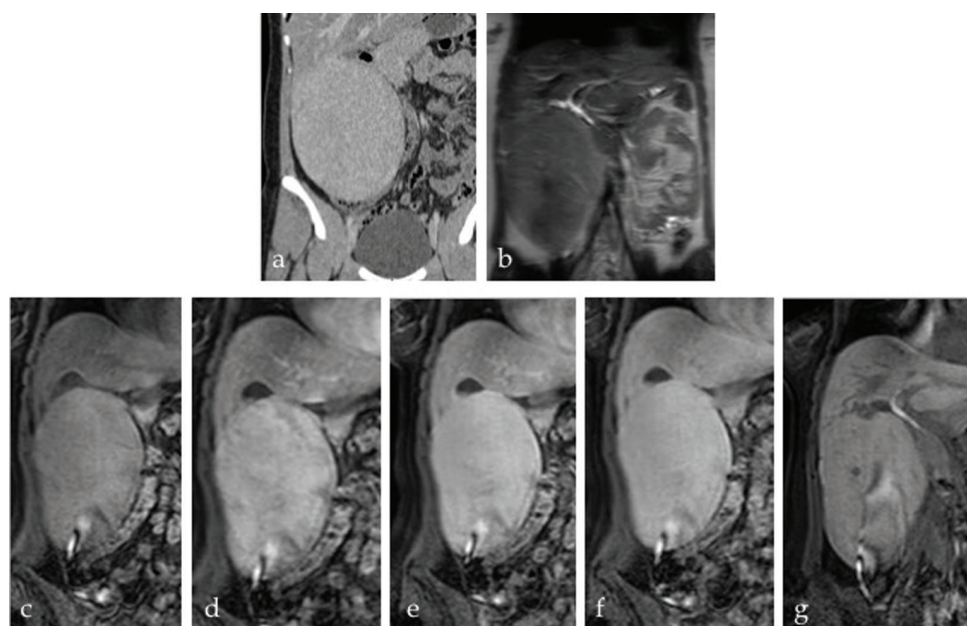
Large exophytic hepatocellular adenoma in a young woman with recent miscarriage, and a prior history of contraceptive pill usage. a. Computed tomography shows a solid liver exophytic mass with background fatty liver. b. T2W coronal image of the lesion. c–f. Arterial to delayed phase shows sustained enhancement with no washout. g. Hepatobiliary phase shows some retention of contrast which can rarely occur in hepatocellular adenoma.
